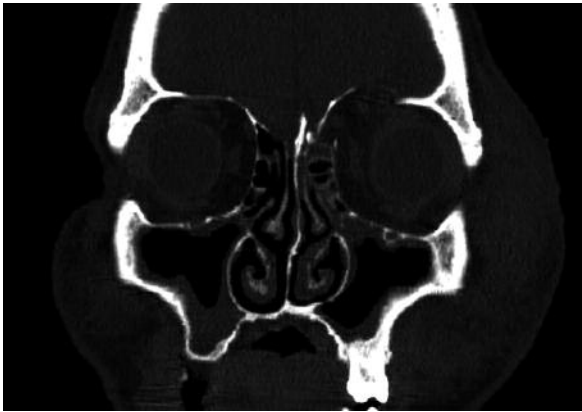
Coronal CT scan showing the displacement of the orbital roof and periorbital edema.
